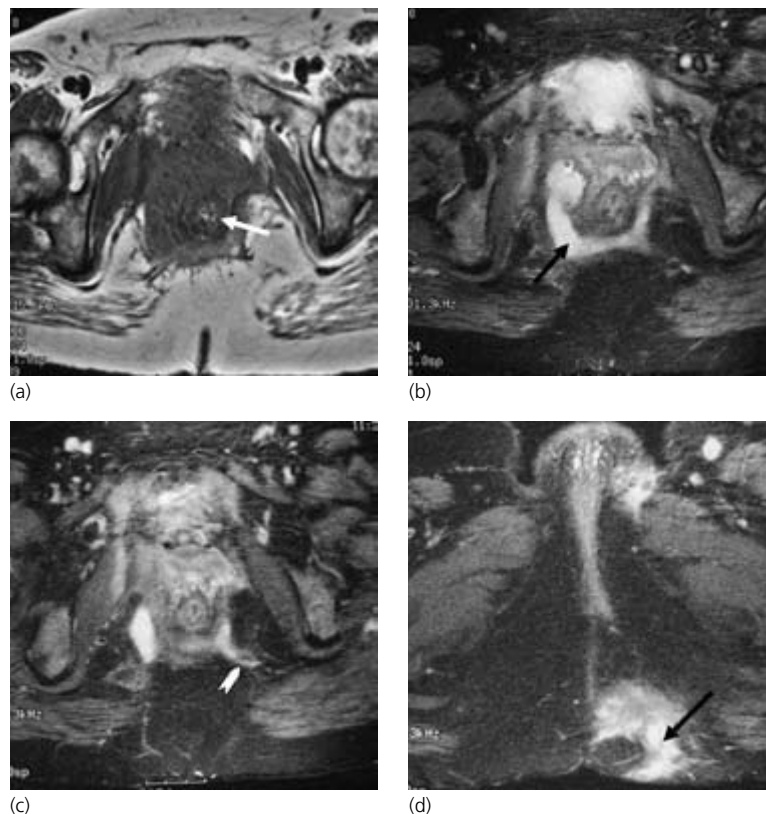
Patient 5. (a,b) T1 and Short Tau Inversion Recovery magnetic resonance imaging (STIR MRI) at the same level demonstrating anal sphincter mechanism (white arrow) and associated posterior horseshoe abscess (black arrow). The abscess involves both ischiorectal fossae. (c) STIR MRI demonstrating fistulous track extending to the left buttock (white arrowhead). (d) STIR MRI demonstrating left buttock abscess (black arrow).
